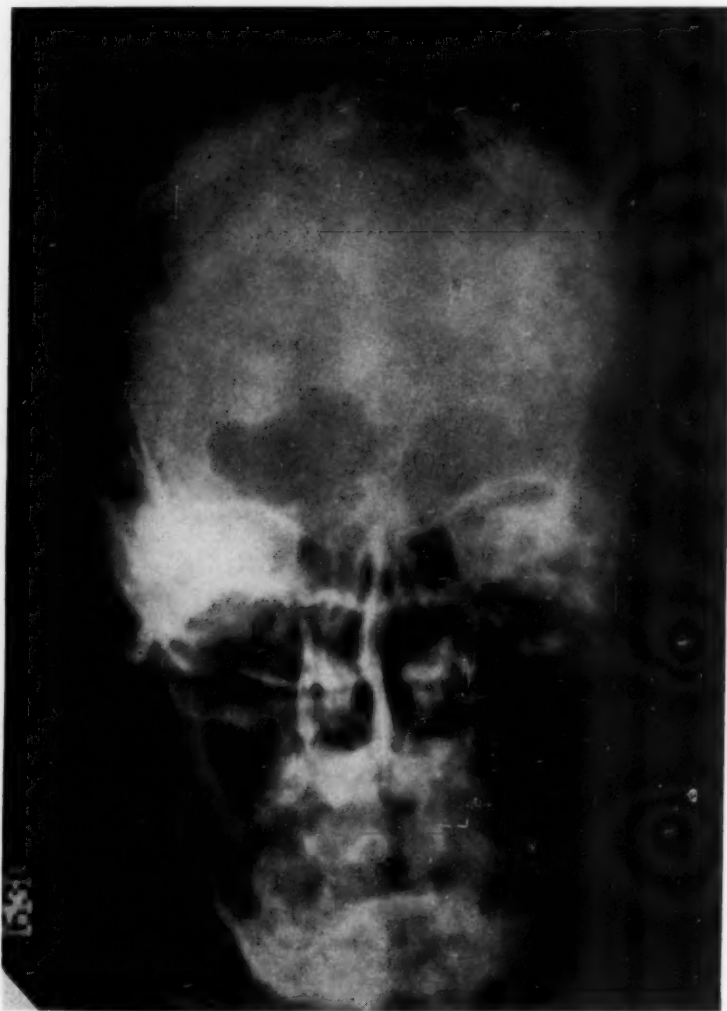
Roentgen-ray studies of the skull show diffuse osteoporotic changes and numerous areas of hyperostosis. The sinuses are enormously enlarged.
